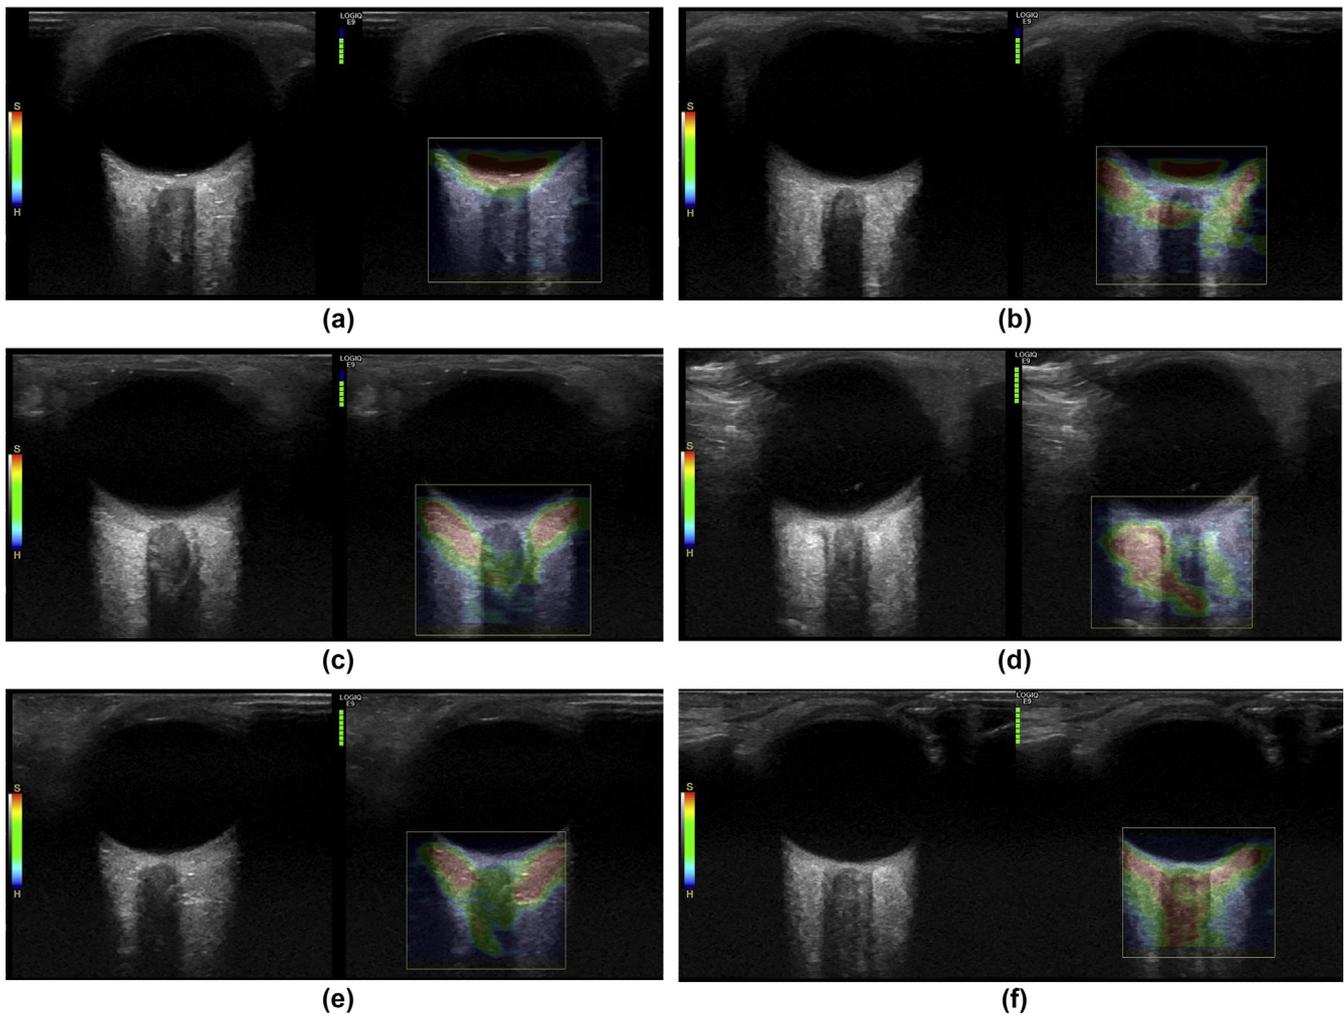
Grey-scale (left) and colour (right) sonograms representing different elastographic patterns of the optic nerve. (a) Type 1a in a 26-year-old patient with pre-eclampsia. (b) Type 1b in a 26-year-old patient with pre-eclampsia. (c) Type 2a in a 22-year-old patient with pre-eclampsia. (d) Type 2b in a 40-year-old patient with pre-eclampsia. (e) Type 3a in a 20-year-old healthy pregnant woman. (f) Type 3b in a 38-year-old healthy pregnant participant.
